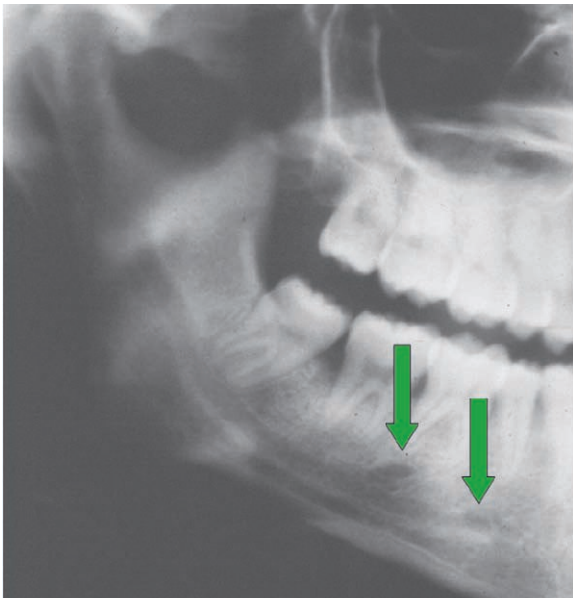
Duplicated mental foramen (detail from panoramic radiograph)
